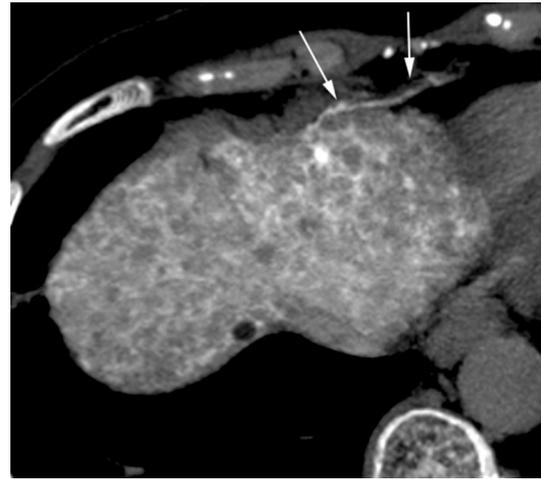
Communication between the superior falciform ligament artery and the hepatic artery demonstrated on the CT during hepatic angiography. Although the apparent long isolated artery was not recognized, the contrast media filled in the liver exuded into the superior falciform ligament artery (arrows) through the capsular arteries
